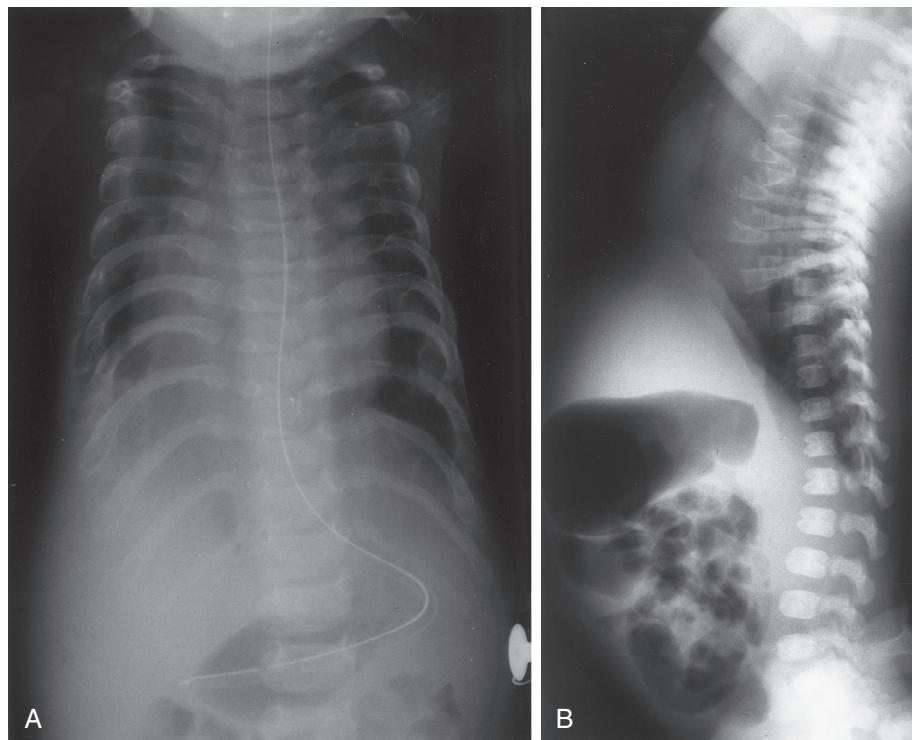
■ Jeune disease (asphyxiating thoracic dystrophy). A, Anteroposterior radiograph shows short horizontal ribs and narrow chest. B, Lateral radiograph demonstrates that the short ribs end at the midaxillary line. Abnormal flaring at the costochondral junctions is also present. The patient died of progressive respiratory insufficiency at 1 month of age. There was no surgical intervention. Postmortem examination revealed alveolar hypoplasia.
